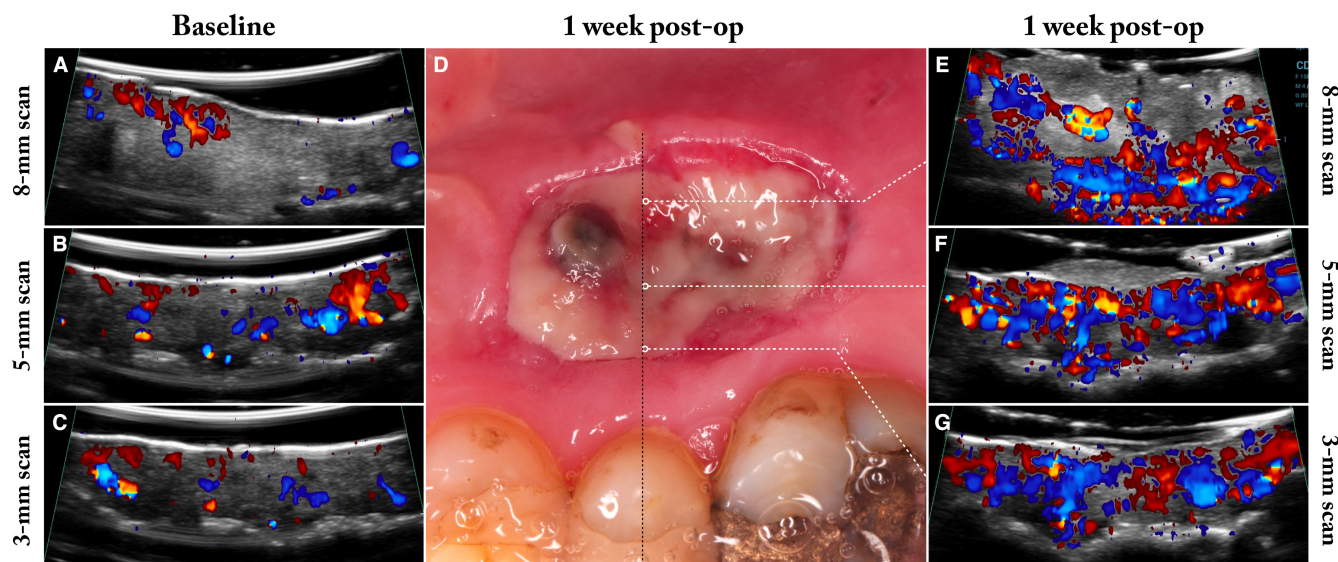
Ultrasound color velocity imaging comparison of vascularization. A, B, C, Presurgical baseline. E, F, G, At 1 week following palatal graft harvesting that had trauma during healing. The patient reported accidental donor-site injury while eating. Image D shows the clinical presentation of the palatal wound at the 1 week post-op. The ultrasonographic color flow mode at 1 week post-op revealed increased perfusion compared with baseline; the 5-mm and 8-mm scans showed a lack of superficial wound vascularization, which may be impeded by inflammatory infiltrate and cell debris. In this case, revascularization of the area started from the deepest layers
